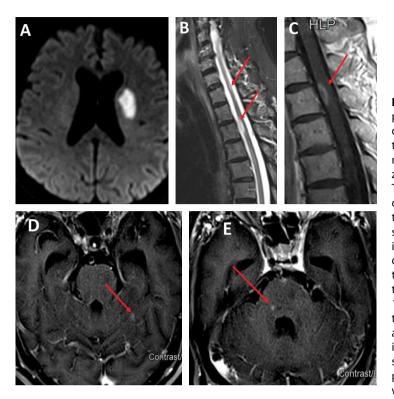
A 76-year-old patient was admitted at our department with a two-day history of diplopia and gait disturbance. Twenty days before admission he had been treated with empiric antibiotic therapy for an upper tract respiratory infection with concurrent headache and dizziness. His medical history was otherwise unremarkable. The neurologic assessment revealed mild confusion and deterioration in time, horizontal diplopia, right central type facial nerve paresis, right sided hemiparesis, and a sensory level at C7-C8. Brain MRI disclosed an acute infarct in the left middle cerebral artery territory (Panel A). In addition, a spinal cord MRI, with contrast injection, showed two enhancing intramedullary lesions in the cervical and thoracic spinal cord levels (Panel B&C). CSF disclosed 150cells/mm and elevated protein levels (126mg/dl), therefore an empiric antibiotic therapy with ceftriaxone, acyclovir and vancomycin for meningoencephalitis was initiated. A repeat brain MRI scan two days later demonstrated multiple foci of parenchymal enhancement in the pons and the left cerebellar hemisphere (Panels D&E), as well as diffuse leptomeningeal enhancement. High dose
